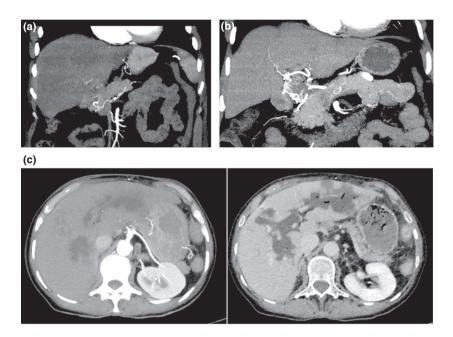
(a) Asymptomatic presentation: A 56-year-old female who developed a LHAT 8 months after LT for cirrhosis and hepatocellular carcinoma. She had no symptoms at diagnosis and still remains asymptomatic after a 4-year follow-up. (b) Mild presentation: LHAT in a 54-year-old patient, 20 years after LT for idiopathic cirrhosis, revealed by acute cholangitis and intrahepatic stones. CT scan showed arterial cavernoma. He underwent a clearance of biliary tree and hepatico-jejunostomy. He is symptom-free since 10 years. (c) Severe presentation: A 67-year-old female, hospitalized for sepsis and multiple liver abscesses secondary to LHAT 31 years after LT for primary sclerosing cholangitis. She was enlisted after prioritization and was successfully retransplanted 1 month after LHAT diagnosis.
